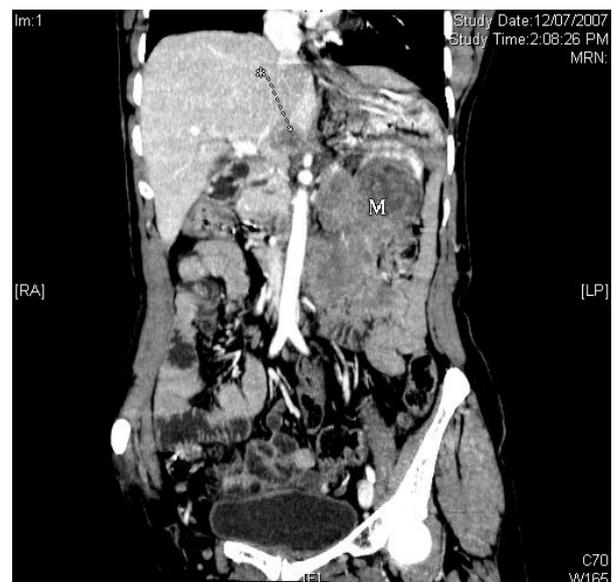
Coronal reformat obtained on a 16 slice multidetector computed tomography scanner showing caudate lobe metastasis (*) and the recurrent SPT in the left kidney and adjacent retroperitoneum and mesentery (M).
